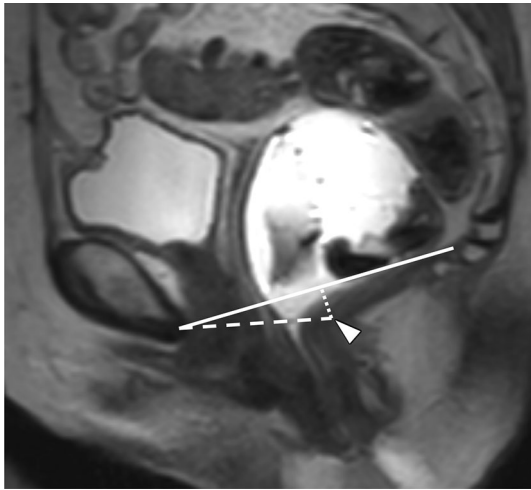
Reference lines. Sagittal T2-weighted image demonstrates placement of reference lines. Pubococcygeal line (PCL, solid line) extends from the inferior pubis to the last coccygeal joint. H-line (long-dashed line) extends from the inferior pubis to the posterior rectal wall at the anorectal junction (arrowhead). M-line (short-dashed line) is perpendicular to the PCL from the posterior aspect of the H-line
